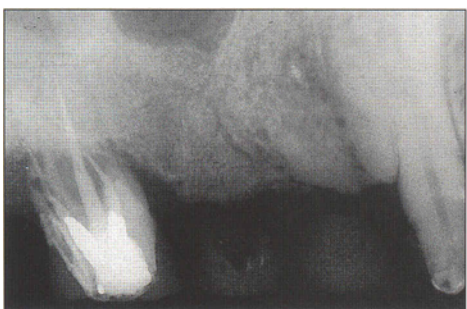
Eight-month post-elevation radiograph. There is increased radiopacity in the location of the extracted premolar and an addition of bone in the area previously occupied by the maxillary sinus.
